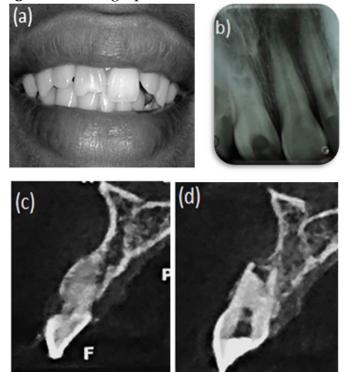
Radiographic examination. Bahia, 2020.
